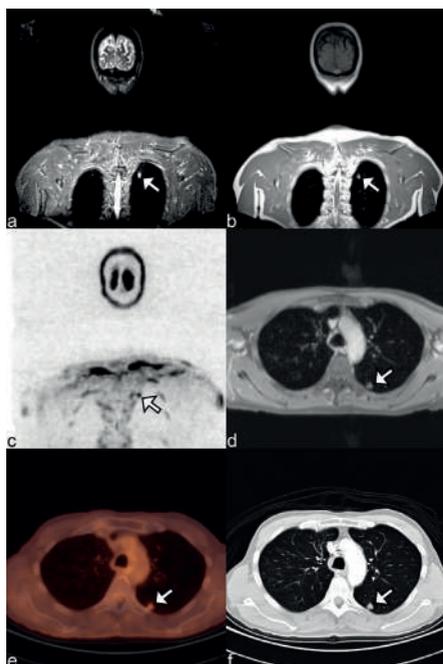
Coronal and axial images in a 62-year old male with a lung metastasis in the apex of the left lower lobe (arrow). A) Coronal STIR, B) coronal T1, C) DWIBS, D) axial contrast-enhanced T1, E) axial fused ^{18}F -FDG-PET-CT and F) axial chest-CT. Mainly due to diffusion-restriction on the coronal DWIBS this lesion is suspected to be malignant. The lesion demonstrates ^{18}F -FDG uptake and on chest-CT a solitary non-calcified nodule is seen.
